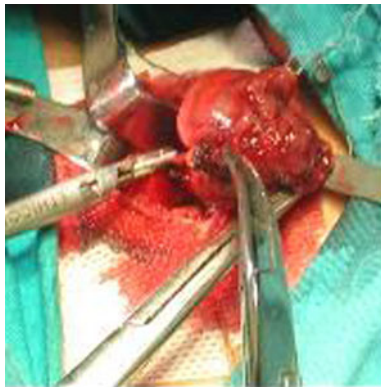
Resection of thyroid lesion with ultrasonic scalpel
